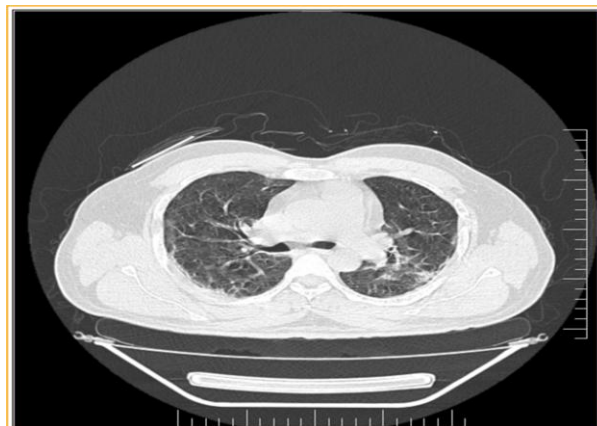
Axial sections of CT chest in a 55 year old patient reveal mixed pattern of both ground glass opacities and consolidation diffusely in both lung fields.
